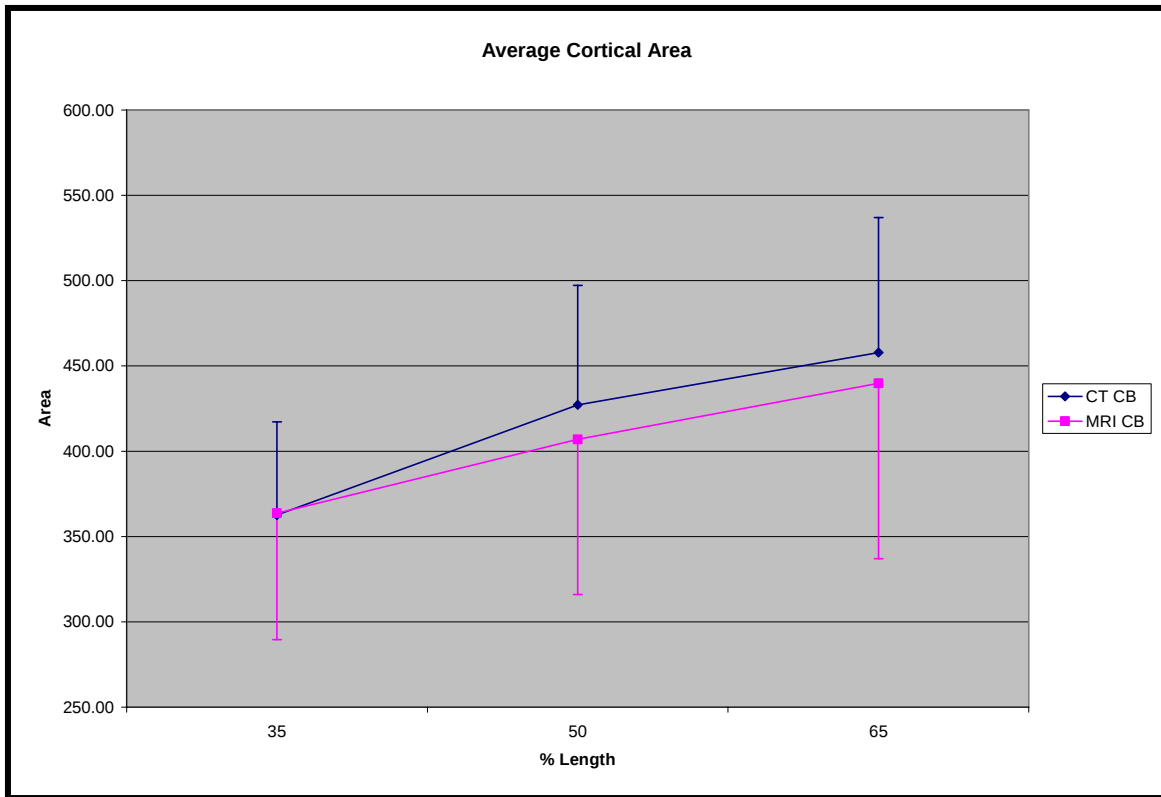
Graph of the average cortical area (with associated standard deviations) calculated from CT and MRI scans. MRI scans underestimated cortical area and had greater standard deviations in the data.
